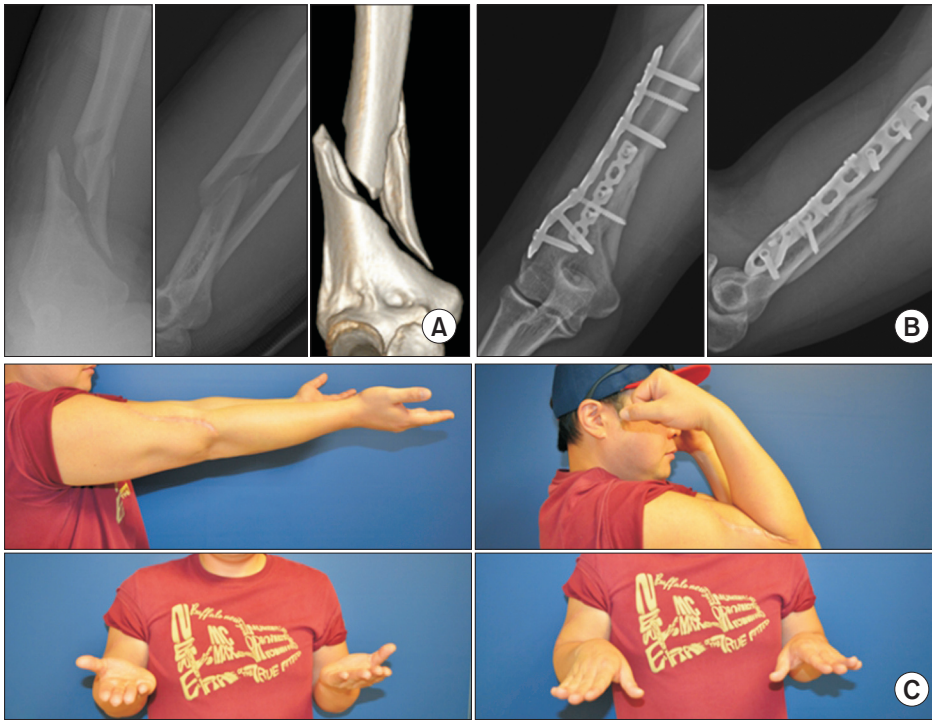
Clinical outcomes of surgical treatment in a 34-year-old man with a distal junctional fracture of the humerus. (A) Preoperative plain radiography and 3-dimensional computed tomography. (B) Postoperative 3-month radiographs showing achievement of bony union. (C) Range of motion showing satisfactory results.
